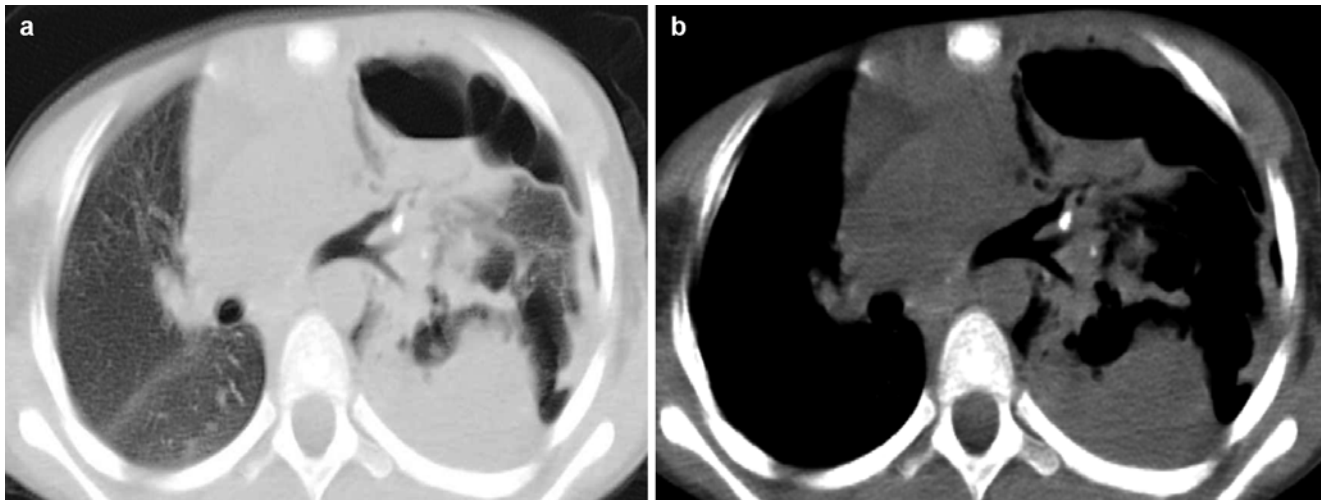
(a, b) A girl aged 7 years with influenza A (H1N1) complicated by pneumonia and cryptococcal infection. (a) At d 7 since onset, plain chest CT scan showed left pneumothorax (*arrow*) in the lung window, shrinkage of the left upper lung lobe, and multiple large flaky high-density opacities at the left upper lung lobe with poorly defined
